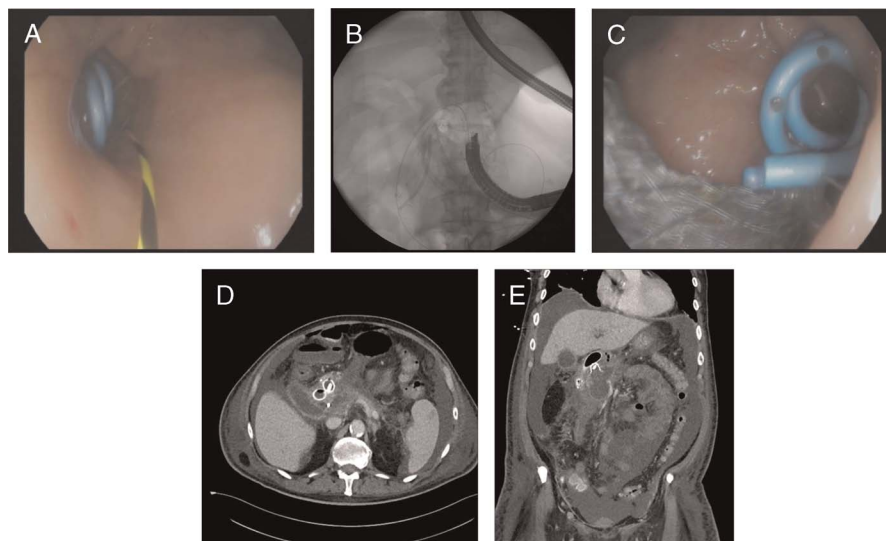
Obstruction of the pylorus by closely applied LAMS into a necrotic pancreatic cavity. A, The LAMS is applied and the lumen is protected by two double-pigtail drainages to avoid food passage into the cavity, and a guidewire is applied next to the LAMS through the pylorus into the duodenum. B, Radiologic view after inserting the fully covered intestinal stent next to the LAMS with two double-pigtail drainages. C, View onto the applied intestinal stent and the visible two double-pigtail drainages into the necrotic cavity. D, Axial CT scan with stents in position—the LAMS can be identified with the double-pigtail drainage in the stent lumen. E, Coronal CT scan of the same area—the intestinal stent can be seen on top of the LAMS with the distal ending in the necrotic cavity. CT: computed tomography; LAMS: lumen-apposing metal stents.
